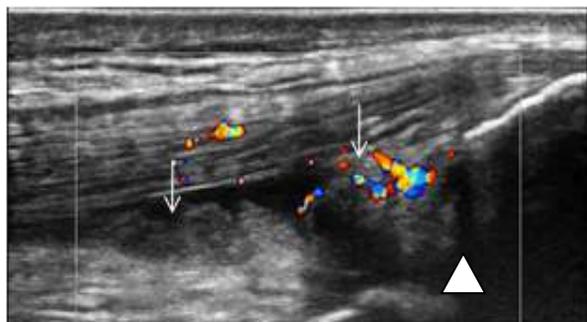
RA patients with different knee joint ultrasound images A: Knee joint for longitudinal sonogram. The white triangle in the figure refers to the non echo area for the bursa Fluid effusion, the white arrow refers to the shape of the low echo of the thickening of the synovial membrane, CDFI showed that the distribution area of the blood flow signal was 1/2 of the thickened synovial zone, and CDFI was 2.
